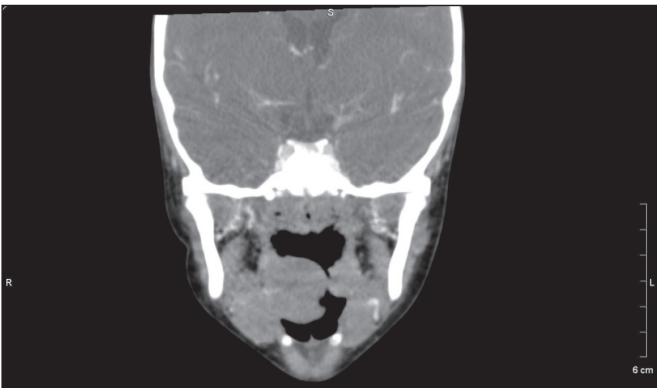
Coronal section of computed tomography of patient 1: evident asymmetry of the palatine tonsils
